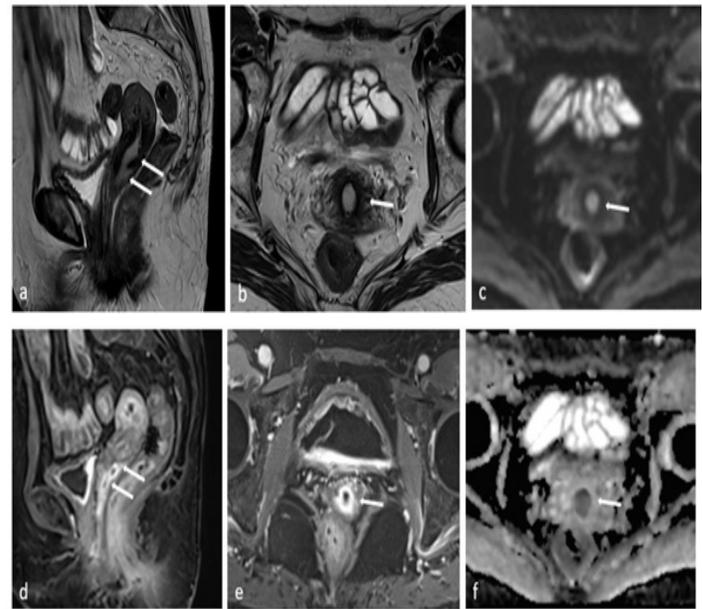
Pelvic MRI (a-f): sagittal T2-weighted (a) shows a cervical mass with an intermediate signal on T2 and well-defined borders. Axial T2-weighted (b) shows that the cervical mass doesn't involve the parametrium. This cervical mass has an early enhancement (arrow) on axial and sagittal T1 post-contrast images (d, e) and a homogenous restricted diffusion on DWI (c) with its respective ADC (f). Moreover, there is no extension to uterus or fallopian tubes. TEP-CT shows an intense uptake in uterine cervix (g).
